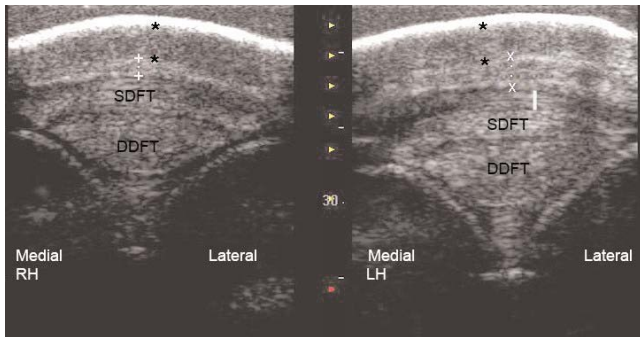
Fig o4: Transverse bilateral ultrasonographic images of the plantar fetlock regions of a 14-year-old pony. In the right hind (RH) image the PAL is thickened (X to X, 4.15 mm) and has loss of fibre pattern compared to the normal ultrasonographic appearance of the left hind (LH) (+ to +, 1.55 mm). Thickening of the DFTS (Digital flexor tendon sheath) is also present in the LH (solid white line). Skin thickness is similar in both limbs (* to *). The relative hypoechoic band to the right of the images reflects a contact artefact. SDFT = Superficial digital flexor tendon; DDFT = deep digital flexor tendon.
